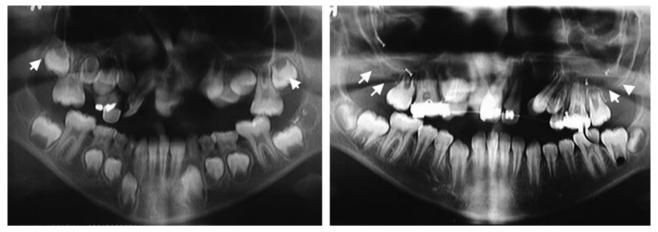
Panoramic radiographs obtained before (13-left) and 2 years after (13- right) maxillary advancement with a rigid external distraction (RED) system. Note creation of space and new bone posterior to the last maxillary molars (double arrows). Also observe continued eruption and root development of the maxillary second molars.
